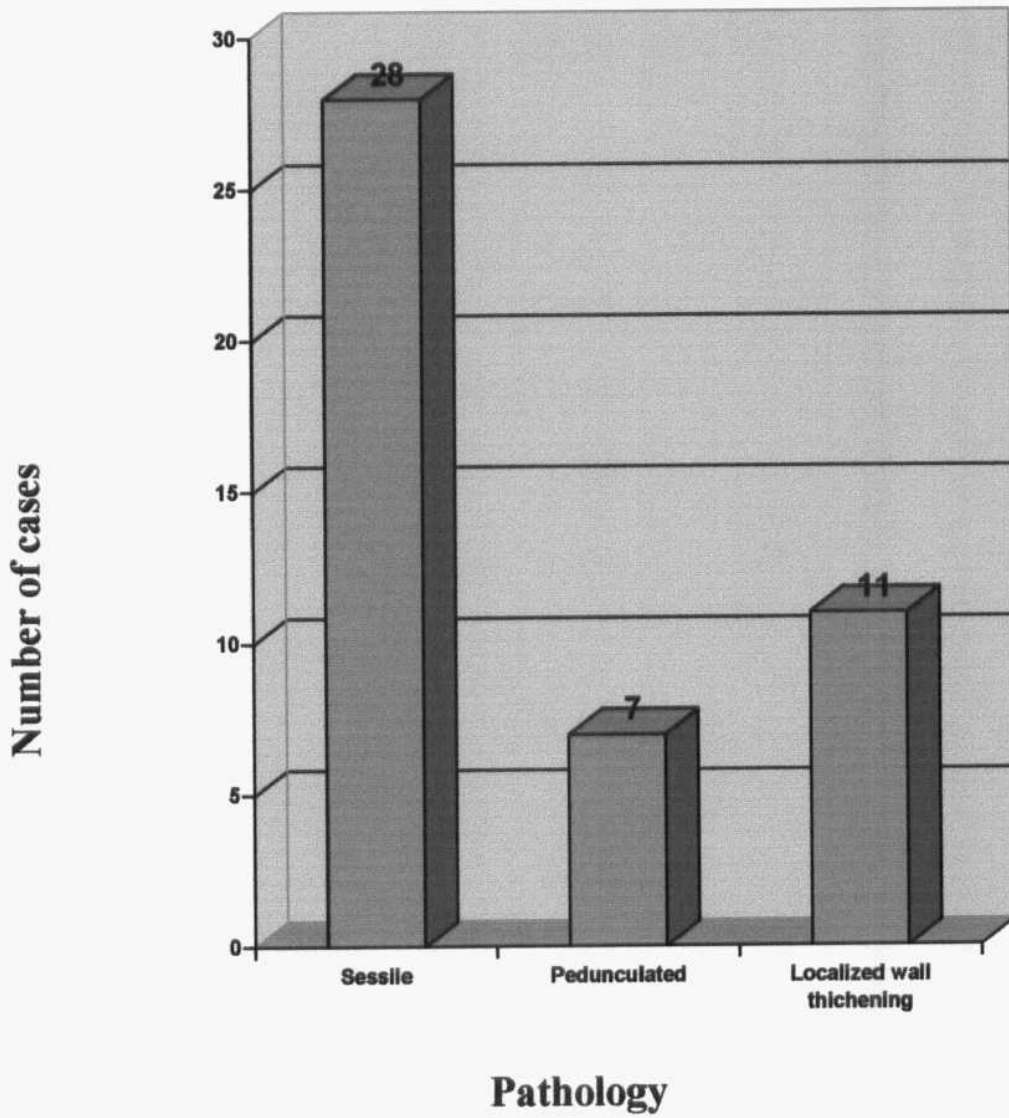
Shape of lesions detected by CT virtual cystoscopy.
